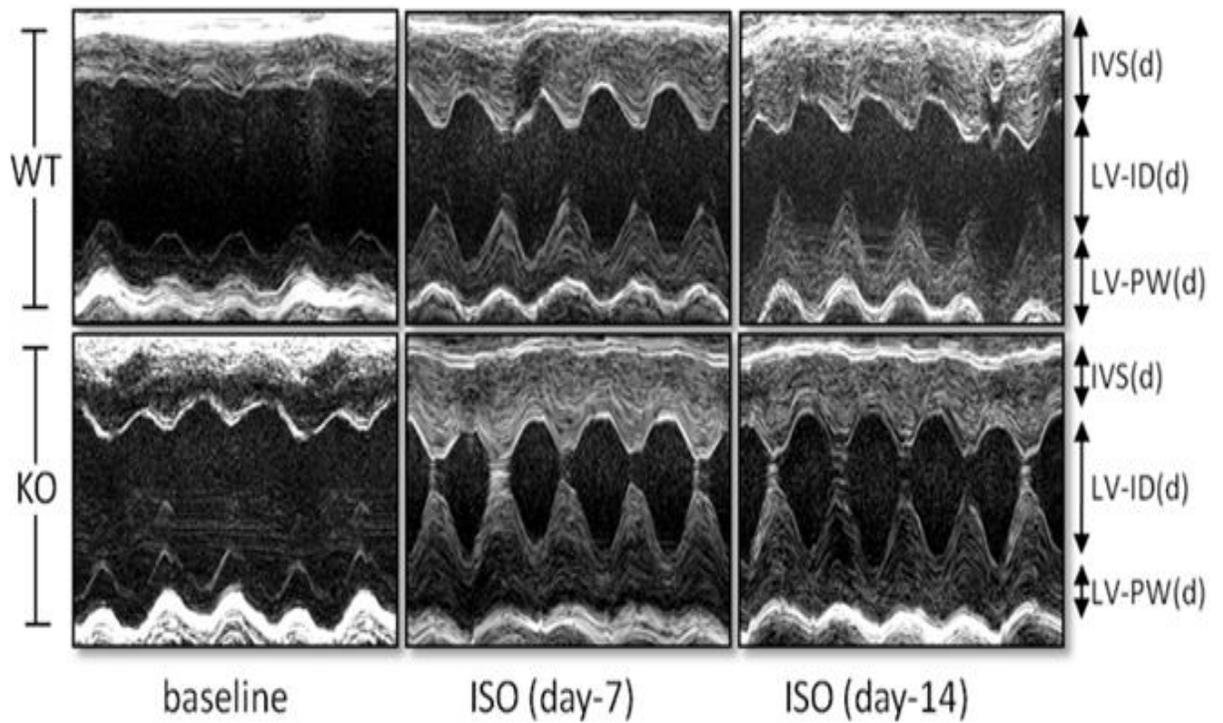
Representative transthoracic echocardiographic M-mode image of the LV from WT and KO hearts at baseline, following 7 days of ISO treatment and following 14 days of ISO treatment (15mg/kg/day). All measurements n=9.
